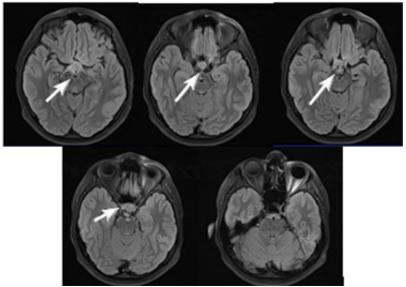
Suprasellar MRI visualizes a lumpy mass with predominant intermediate signal intensity, slightly inhomogeneous obliterating the intrasellar brain structures. Its cranio-caudal dimension is 2.5 cm along with its intrasellar contents/confluent with the pituitary gland.
